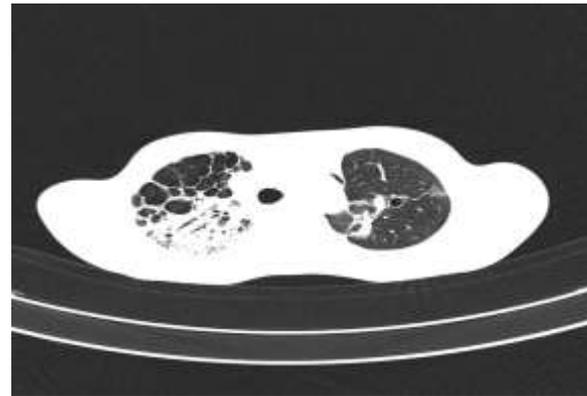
HRCT Chest: honey combing, cystic spaces, predominantly in Right upper lobe with traction bronchiolectasis
